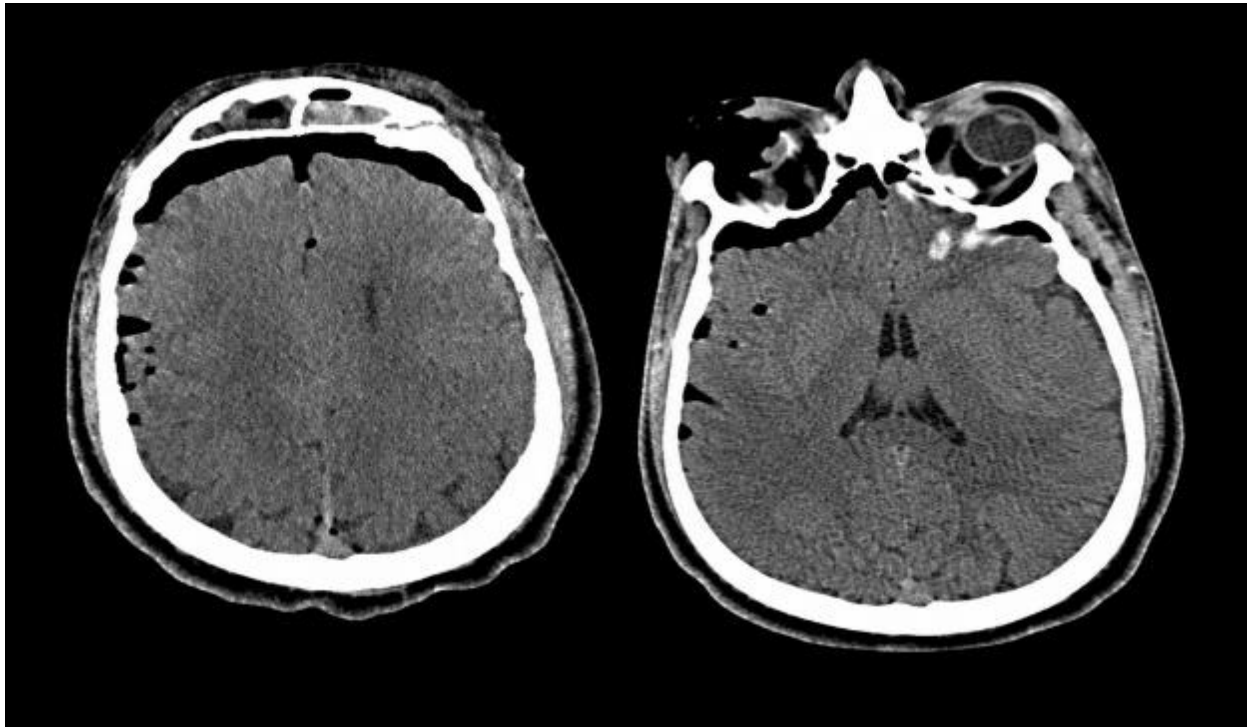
Initial brain CT, axial sections. Presence of frontal pneumoencephaly, associated with traumatic frontotemporal lesions in a context of fractures of the anterior level of the facial mass, suggestive of an osteomeningeal breach. These abnormalities explain the high risk of post-traumatic meningeal contamination.
